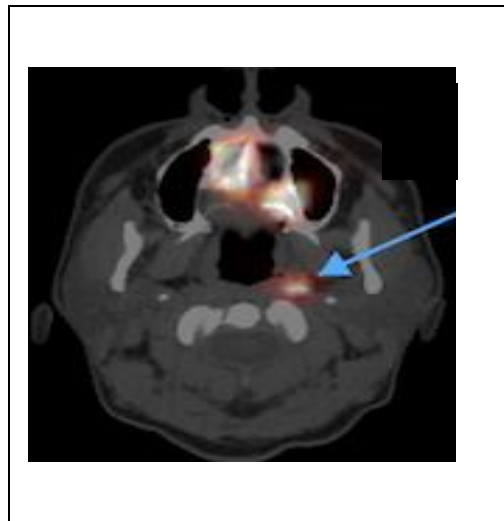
SPECT/CT of left palate tumour showing injection site anteriorly and left parapharyngeal node (arrow)
